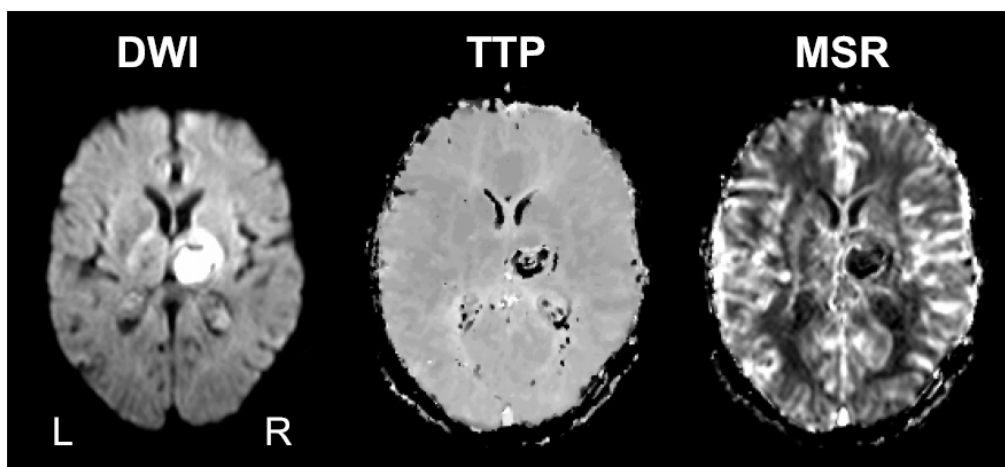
Example of DWI (left), TTP (middle) and MSR (right) maps in a patient with a thalamic lesion. The zone of structurally damaged tissue (thalamus) is clearly visible as an hyperintense area of the DWI map and as a black area of hypoperfusion in the PWI maps.
